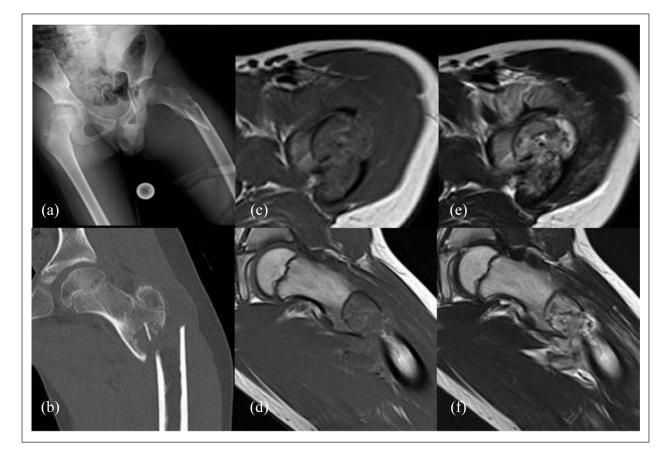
(a) Radiograph showing a subtrochanteric fracture of the left femur with a well-defined geographic lucent lesion that indicated a pathological lesion at the fracture site. (b) Computed tomography scan showing a centrally located well-demarcated metaphyseal lesion with cystic lytic expansion. A bony fragment is observed, suggesting a fallen fragment sign. (c–f) Magnetic resonance images showing low-intensity lesions on TI-weighted (c and e) and T2-weighted (d and f) images (c and e: axial views and d and f: coronal views). Heterogeneity of the lesion is noted with patchy signal changes within the bone marrow lesion.
